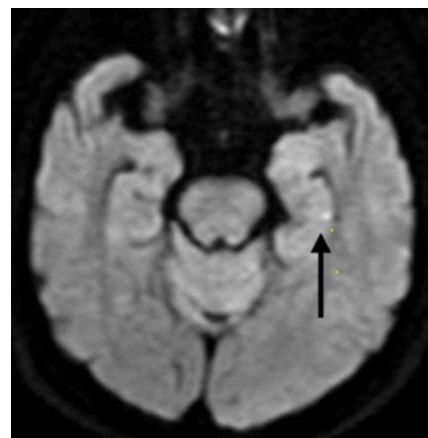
MRI Brain axial diffusion weighted image showing left hippocampal hyperintensity (Hippocampal dot sign) (black arrow). Corresponding apparent diffusion coefficient map showed hypointensity.
